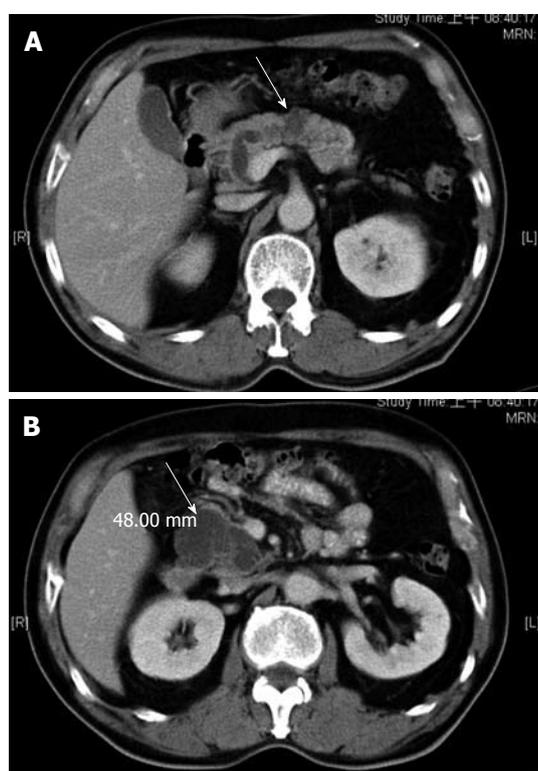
Abdominal computed tomography showing pancreatic head and body cystic tumors (arrow) with no evidence of regional lymphadenopathy or distant metastases.
